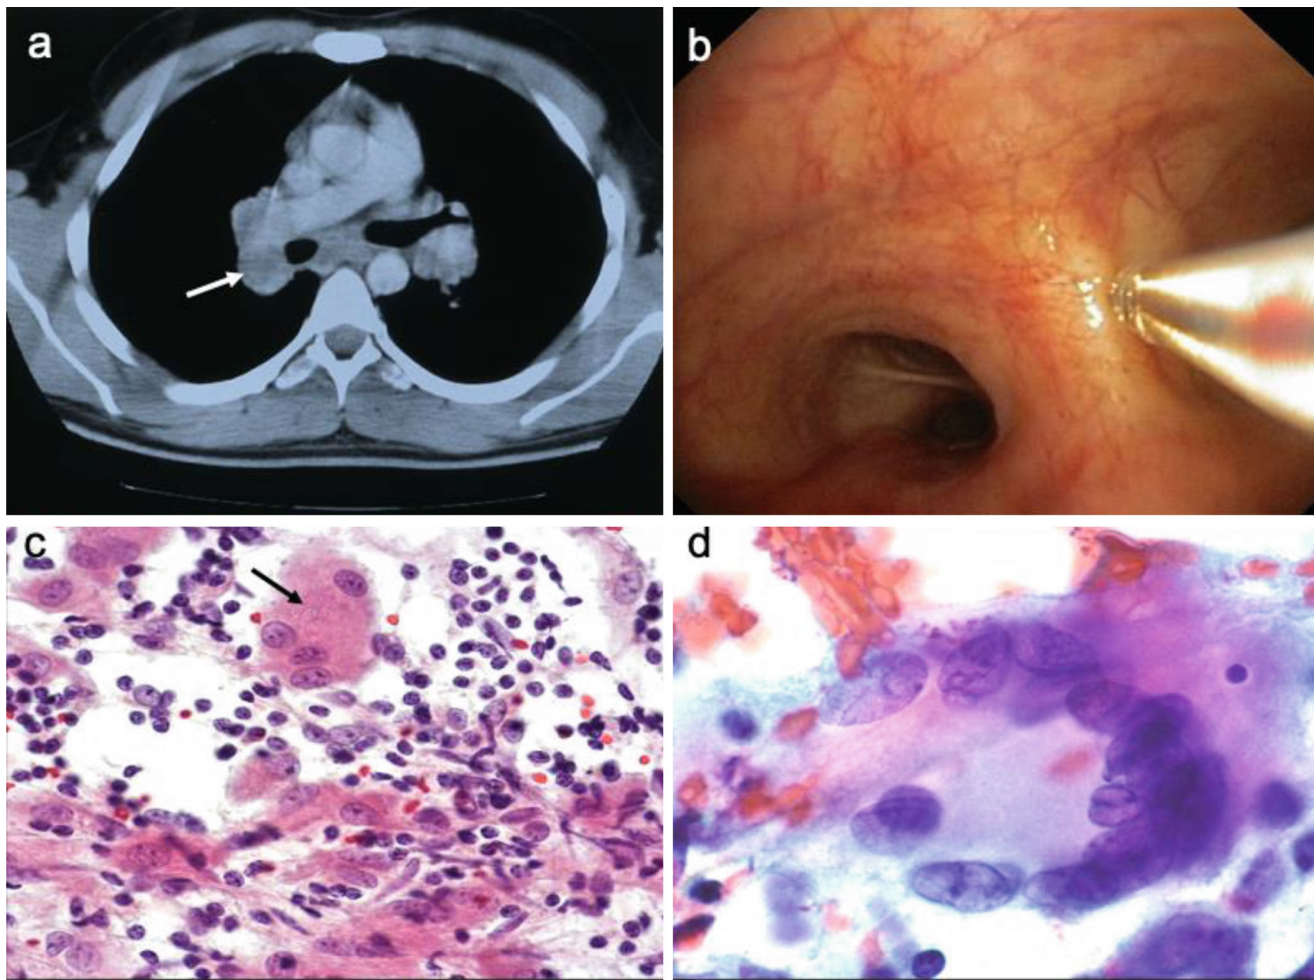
A case of stage I sarcoidosis diagnosed by conventional TBNA. (a) CT scan shows lymph nodes enlargements in subcarinal and bilateral hilar stations. The arrows indicate the right hilar lymph node that was punctured; (b) The needle is inserted in the spur between
